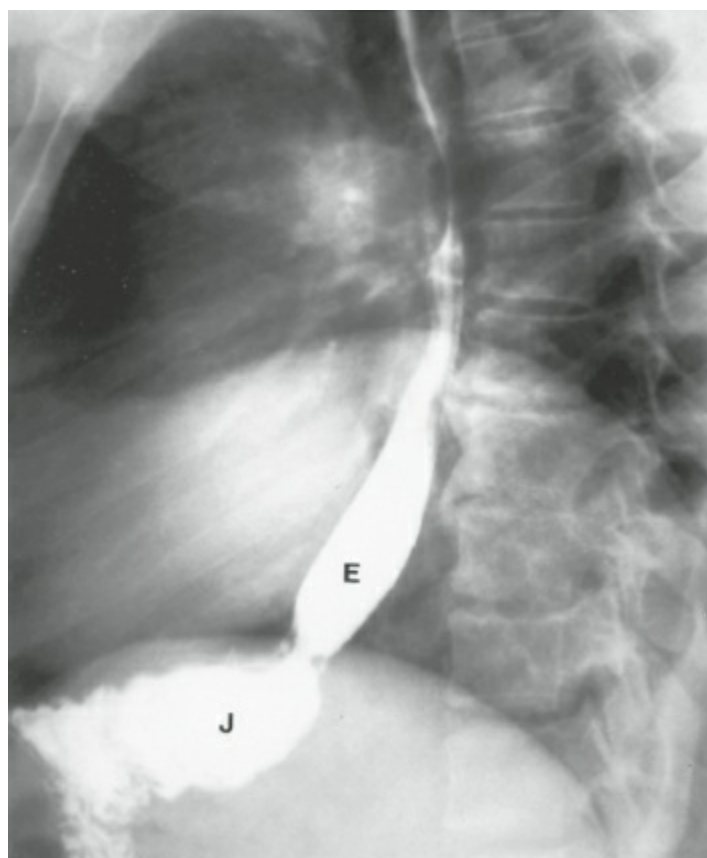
Postoperative radiograph after total gastrectomy with esophagojejunal anastomosis, showing esophagus (E) and jejunum (J).
